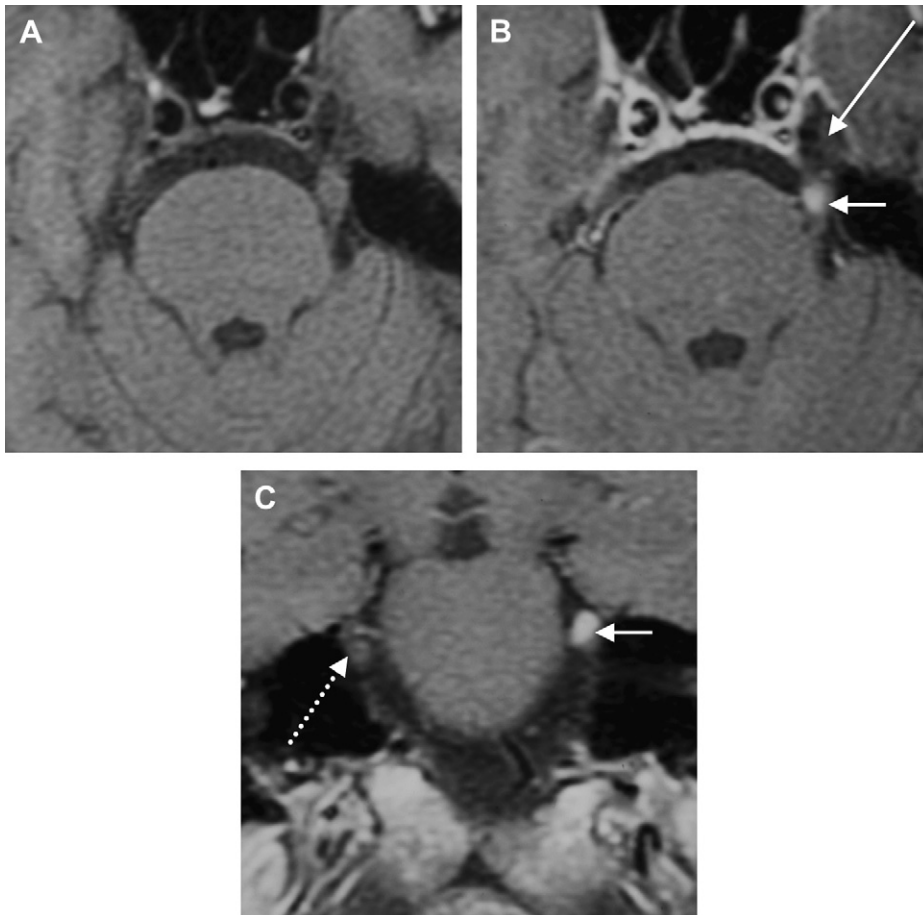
Axial T1-weighted image (A) and postgadolinium axial (B) and coronal (C) T1-weighted images show a small focus of enhancement and slight enlargement of the cisternal segment of the left trigeminal nerve (*short white arrows*), which does not extend into Meckel's cave (*long white arrow in B*). Note the cisternal segment of the right trigeminal nerve (*dashed white arrow in C*). (This focal enhancement disappeared on follow-up scans, and a presumptive diagnosis of neuronitis was made).
